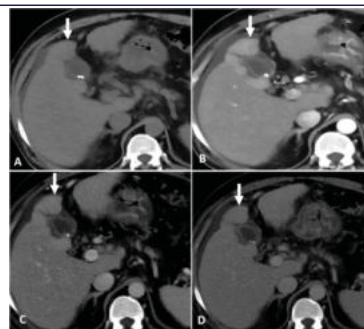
A 63 year-old male patient with cirrhosis having liver nodules. A- Axial plain CT showing cirrhotic liver with multiple isodense lesions in segment V adjacent to GB fossa (arrow). These lesions show arterial phase hyperenhancement (B, arrow) without any additional feature like portal or delayed phase washout (C, D arrows), capsule or threshold growth. These lesions will be characterized as dysplastic nodules while reporting using conventional criteria free approach. However, these lesions falls directly under probable HCC (LI-RADS 4) category as this arterial phase hyperenhancing lesion measures more than 20 mm (largest lesion size -23 mm).
